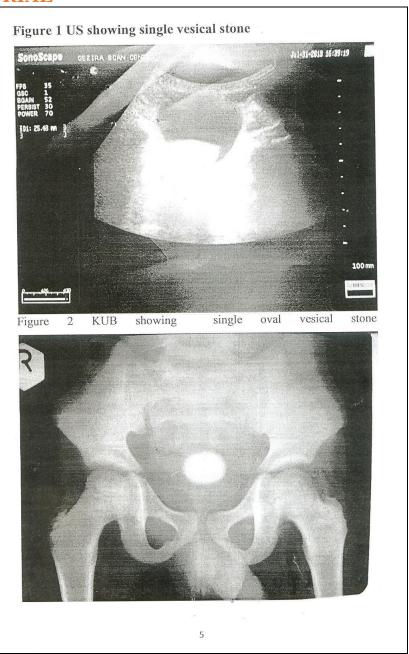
Ultrasound showing a single vesical stone
